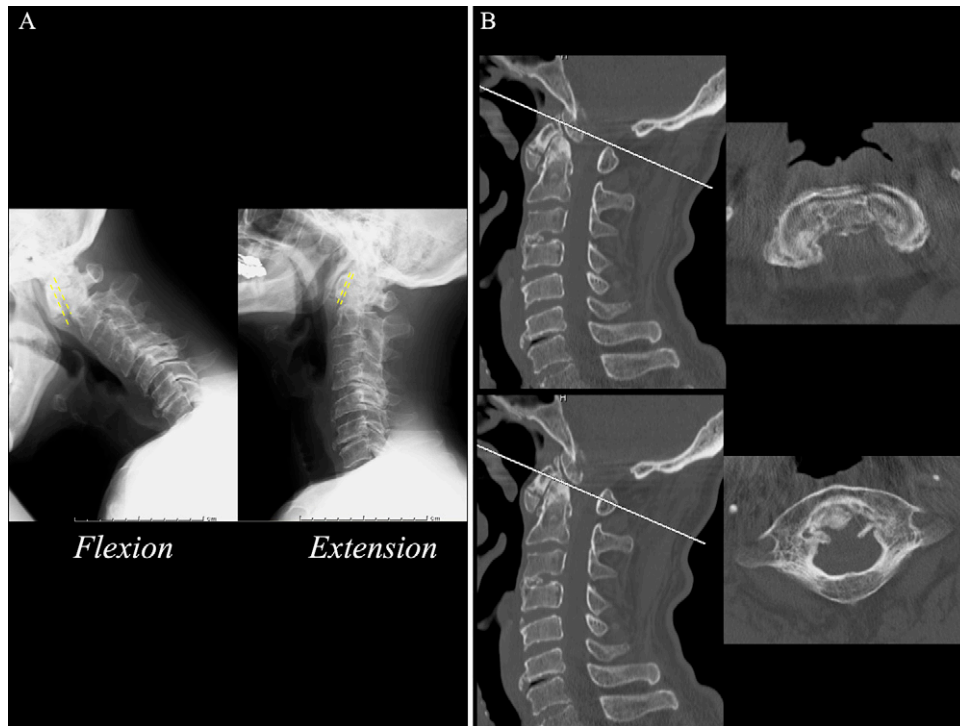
Preoperative radiographs and CT scans. A: The atlantodental interval widened, and the posterior arch of the atlas moved forward in the neck flexion position. B: Ectopic ossification around the C1 anterior arch, C2 process, and anterior longitudinal ligament in the lower cervical spine. These findings implicated mechanical stress caused by atlantoaxial instability.
